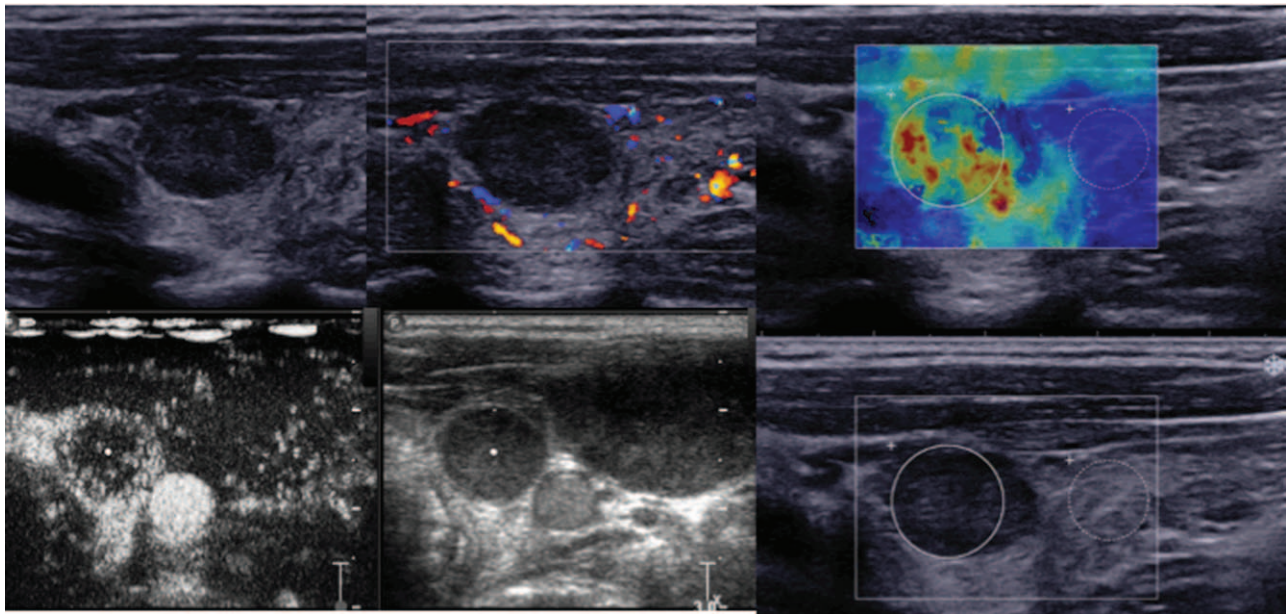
Multimode ultrasonic features of the nodule in the left lobe in a 42-year-old woman with adenoid cystic carcinoma of the submaxillary gland metastasized to the thyroid.
